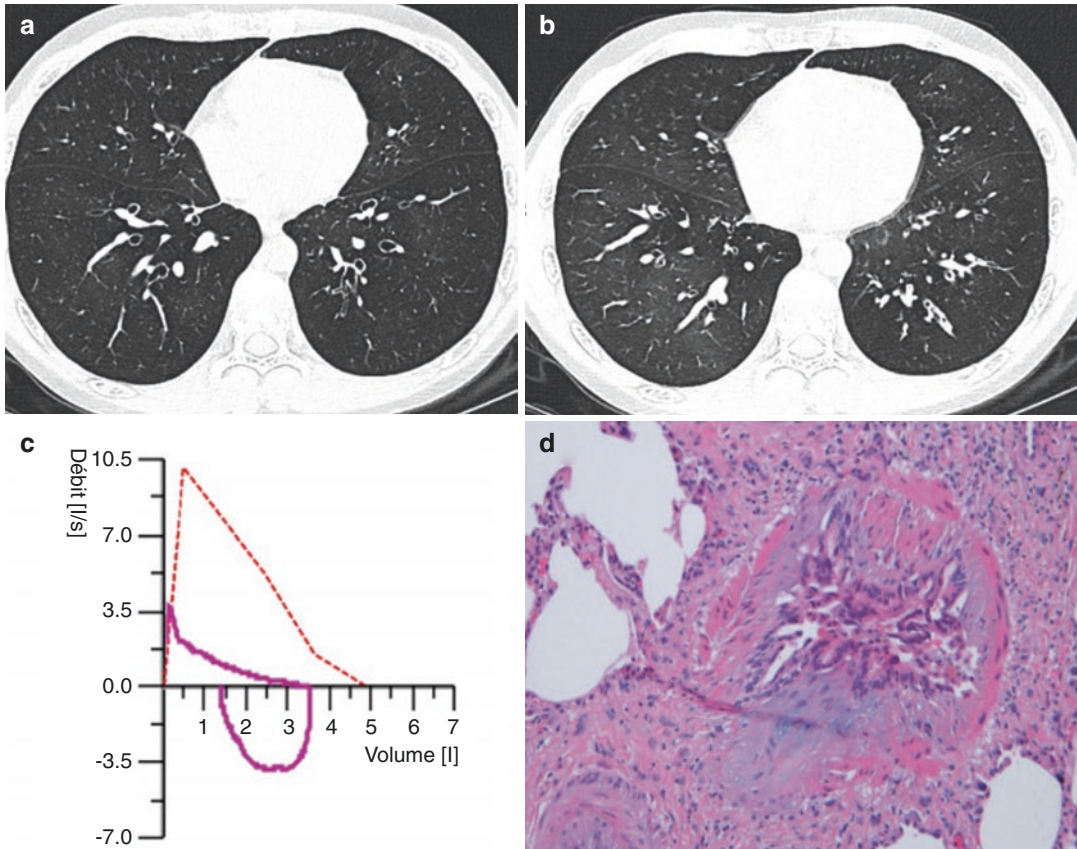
Diagnosis of bronchiolitis obliterans in allogeneic HSCT recipients. Inspiratory chest CT scan (a) showing heterogeneous lung parenchyma and air trapping on forced expiration (b). Flow-volume loop showing a
